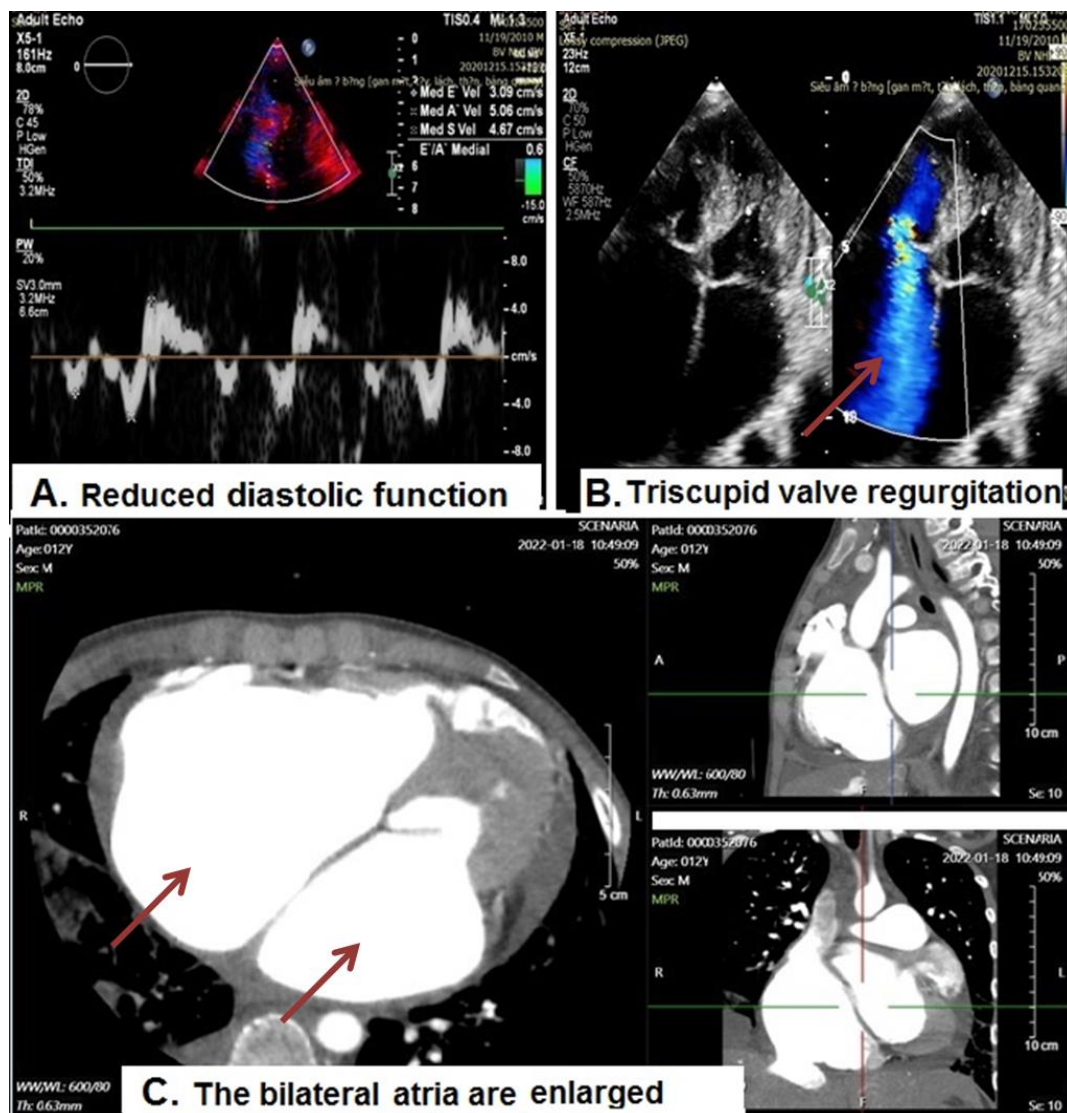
A, B: The echocardiography showed greatly dilated atria, non-dilated ventricles, normal systolic function, grade 3/4 mitral regurgitation, grade 2/4 tricuspid regurgitation, left ventricular diastolic failure; C: Magnetic resonance imaging of the heart and large blood vessels showed no images of pericardial thickening, no signs of pericarditis, no structural malformations of the heart and large extracardiac blood vessels, and normal coronary artery origin
